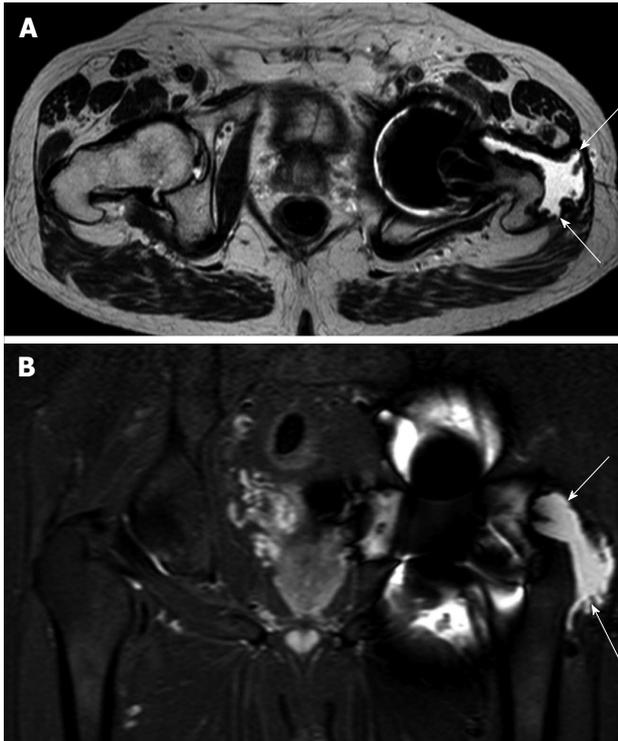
Axial (A) and coronal (B) magnetic resonance imaging. Example of abductor stripping secondary to a pseudotumour (marked by arrows). The pseudotumour can be seen traversing the posterior hip around the greater tuberosity onto its lateral aspect, which is now void of abductor tendon insertion.
